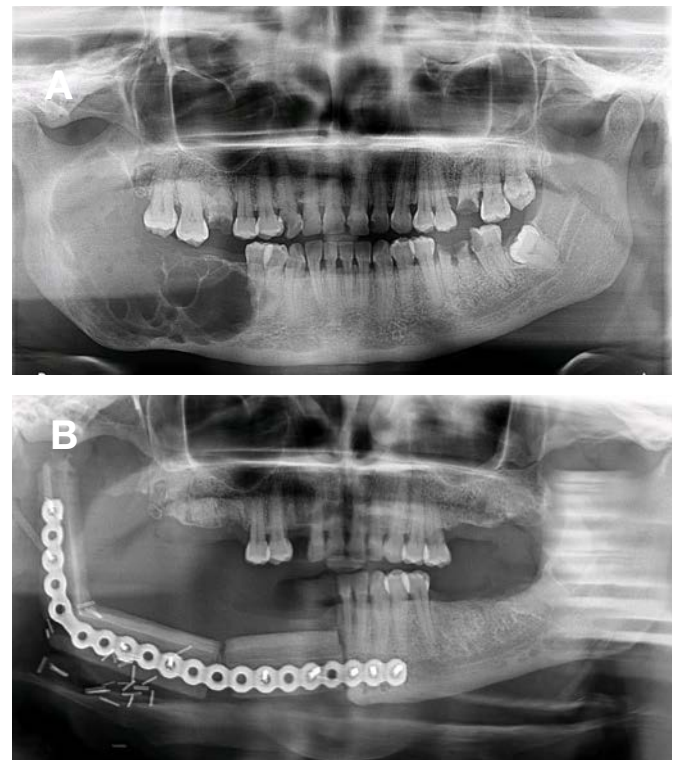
Panoramic radiographs showing (A) Conventional ameloblastoma affecting the right posterior mandible and (B) Hemi-mandibulectomy and fibula free flap with titanium reconstruction plate used to reconstruct the mandible.
